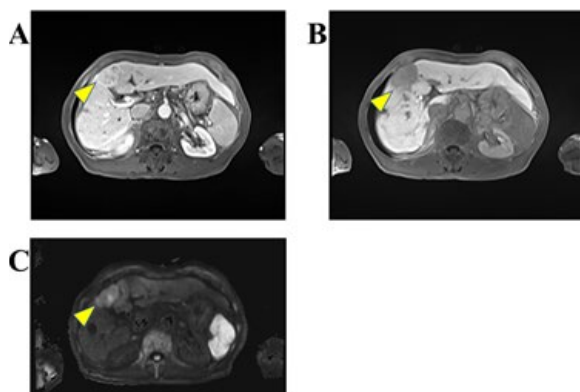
Gd-EOB-DTPA-enhanced MRI showing a well-enhanced lesion after the portal phase (yellow arrowhead) (A) and a low signal intensity lesion in the hepatobiliary phase (yellow arrowhead). (B) On DWI, the signal was not high (yellow arrowhead). (C) MRI, magnetic resonance imaging; Gd-EOB-DTPA, gadolinium ethoxybenzyl diethylenetriamine pentaacetic acid; DWI, diffusion-weighted imaging.
